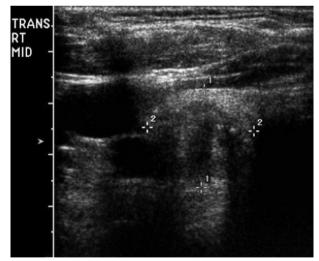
Transcutaneous ultrasound images of the thyroid lesion.
